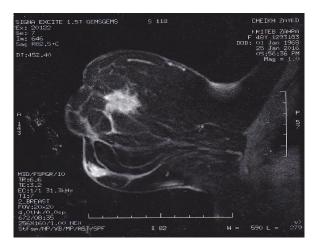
Breast MRI confirmed the suspected character of the right breast lump in addition of another suspected small lesion localized inferiorly.
